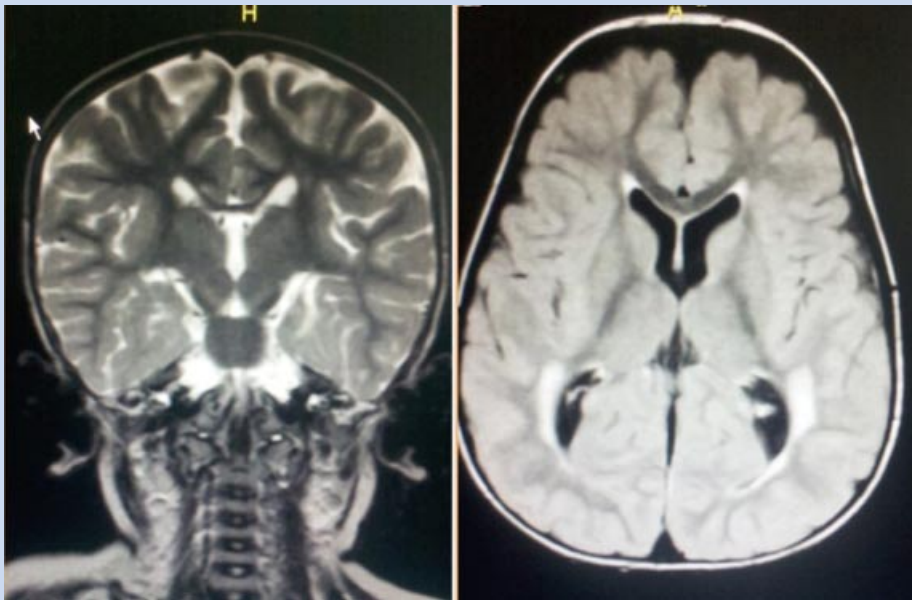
Patient's brain MRI. Note aberrant sulcation of the inferior surface and deep transverse clefts in the mesial temporal lobe.
